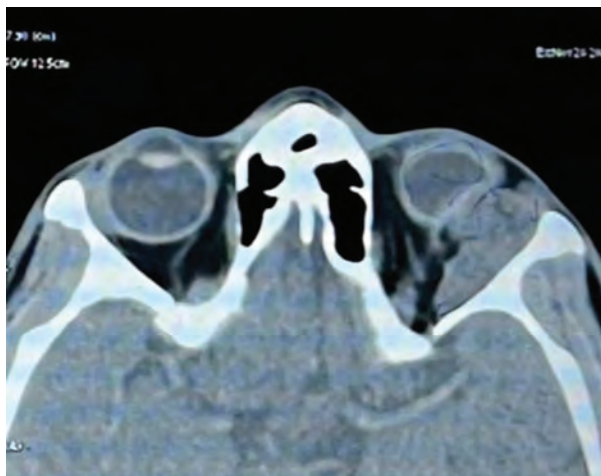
MRI shows the presence of an intraorbital hematoma compressing on the left globe.
